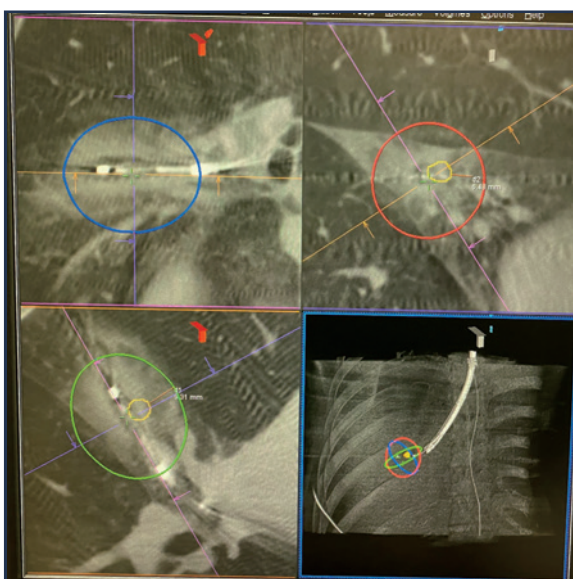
A post-ablation CBCT confirms the ablation zone and margins (Clinical photos from personal collection)
